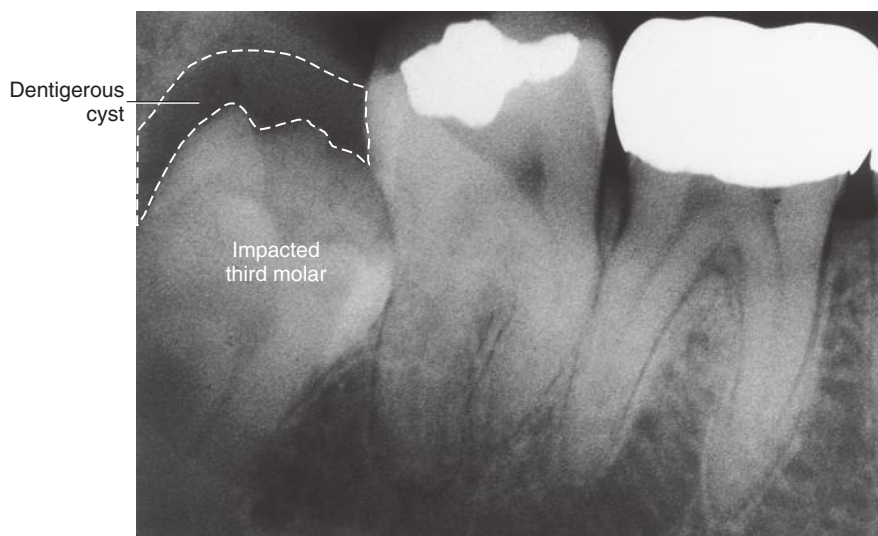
Radiograph of a dentigerous cyst (*dashed lines*) that is formed around the crown of an unerupted permanent mandibular third molar as a result of impaction. (Courtesy of Margaret J. Fehrenbach, RDH, MS.)
